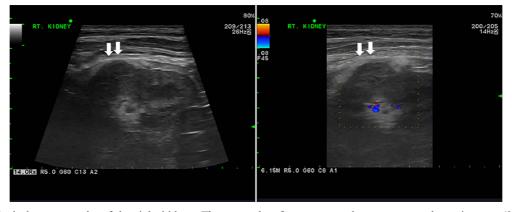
Abdominal ultrasonographs of the right kidney. Three months after surgery, a heterogenous echogenic mass $(2.2 \times 1.5 \text{ cm})$ in the right renal cortex was observed (arrow).
